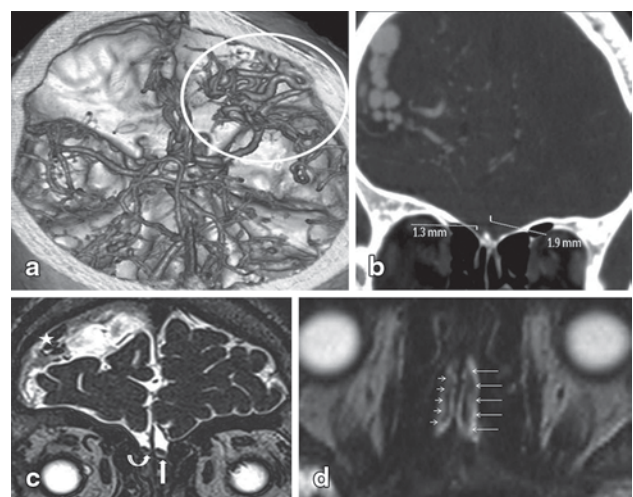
a Volume rendering image of the multidetector CT angiography after cranial vault removed, an AVM located at the frontobasal and lateral region of the right frontal lobe is seen (white circle). Increased in caliber MCA and ACA branches are also delineated. b On coronal multidetector CT angiography image, the right orbitofrontal artery is smaller than the left orbitofrontal artery in caliber. Enhancement of the feeding arteries and draining veins of the AVM are well delineated at the right frontal lobe. c Coronal 3D T2 STIR SPACE image shows a small caliber right OB (curved arrow) and normal caliber left OB. Note that, draining veins of the AVM (star) and frontal lobe volume loss adjacent to the AVM are also seen. d Axial 3D T2 STIR SPACE image shows the small size right OB (small arrows) and the normal size left OB (long arrows).
